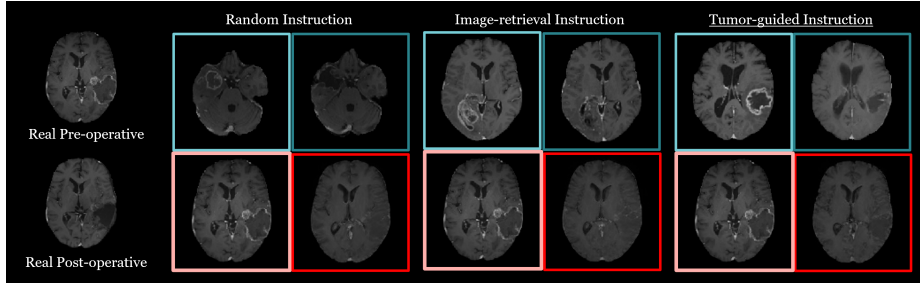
Qualitative results from the ablation study comparing retrieval strategies for visual in-context learning in post-operative MRI generation.
